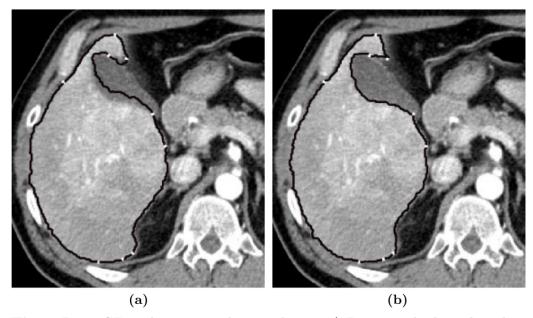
Liver CT with segmented parenchyma: a) Image with shape-based interpolated contour and approximated seed points from the two adjacent user-defined slices; larger deviations occur at the gall bladder (dark gray) b) contour after automated optimization.
